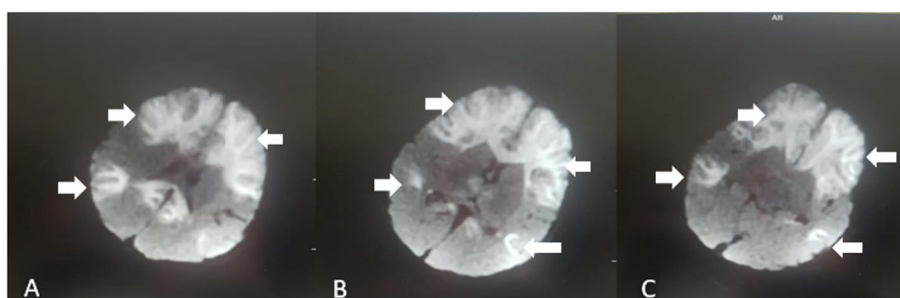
A-C Cranial magnetic resonance image of a patient with encephalitis caused by herpes simplex virus type 1 shows bilateral frontotemporal cerebral parenchymal diffusion restriction (arrows)
